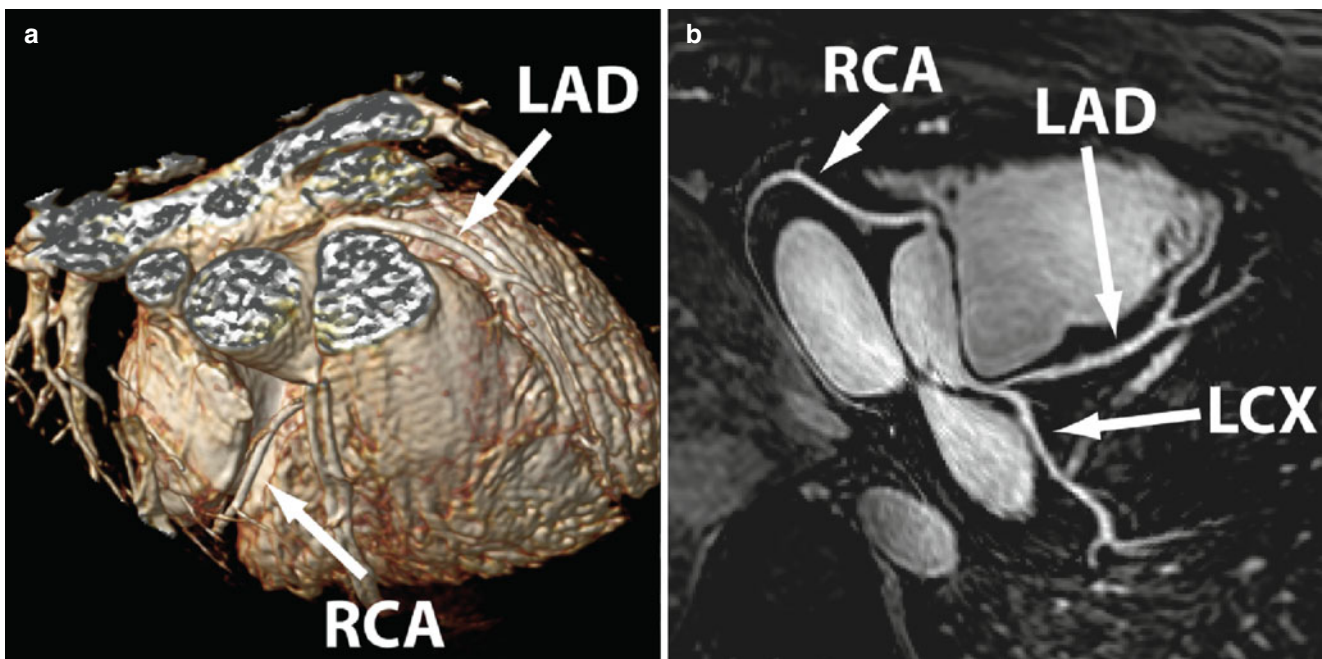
Whole heart SSFP coronary MRI acquired with a bolus injection of Gd-BOPTA. (a) 3D volume rendering of the acquisition volume. (b) Corresponding reformatted whole-heart image. All three
